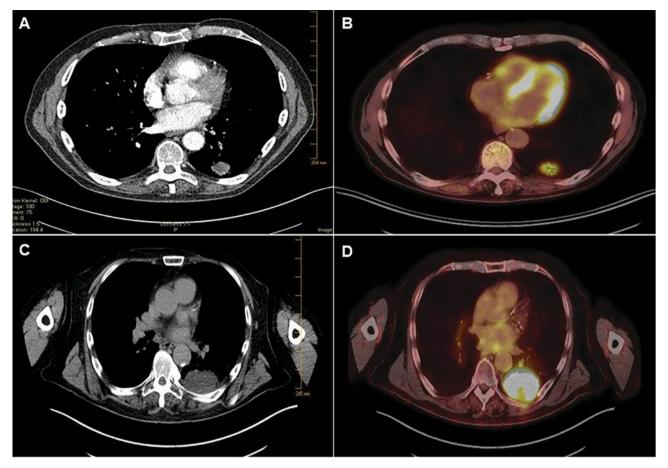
Radiographic findings of the lung mass. (A) CT scan performed in April 2018 in a 67-year-old man. A 1.2 cm left lower lobe pulmonary mass was seen; (B) PET/CT scan done in April 2018 showing the FDG avid mass; (C) CT scan and (D) PET/CT scan performed in September 2019 showed enlargement of the mass suggesting progression of malignancy. A 2.5 cm left lower lobe pulmonary mass was seen.
